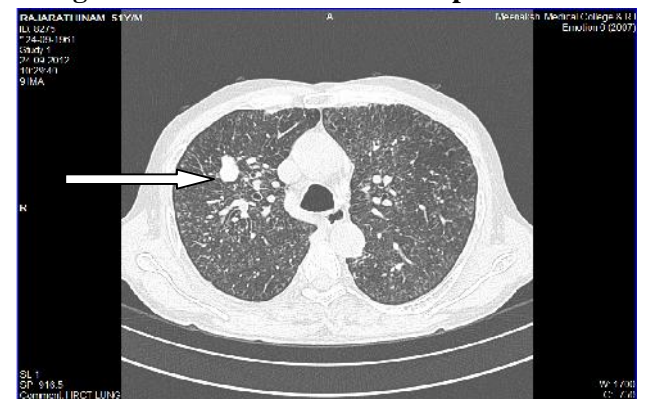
HRCT Chest showing a conglomerate nodule in the right apical segment.
